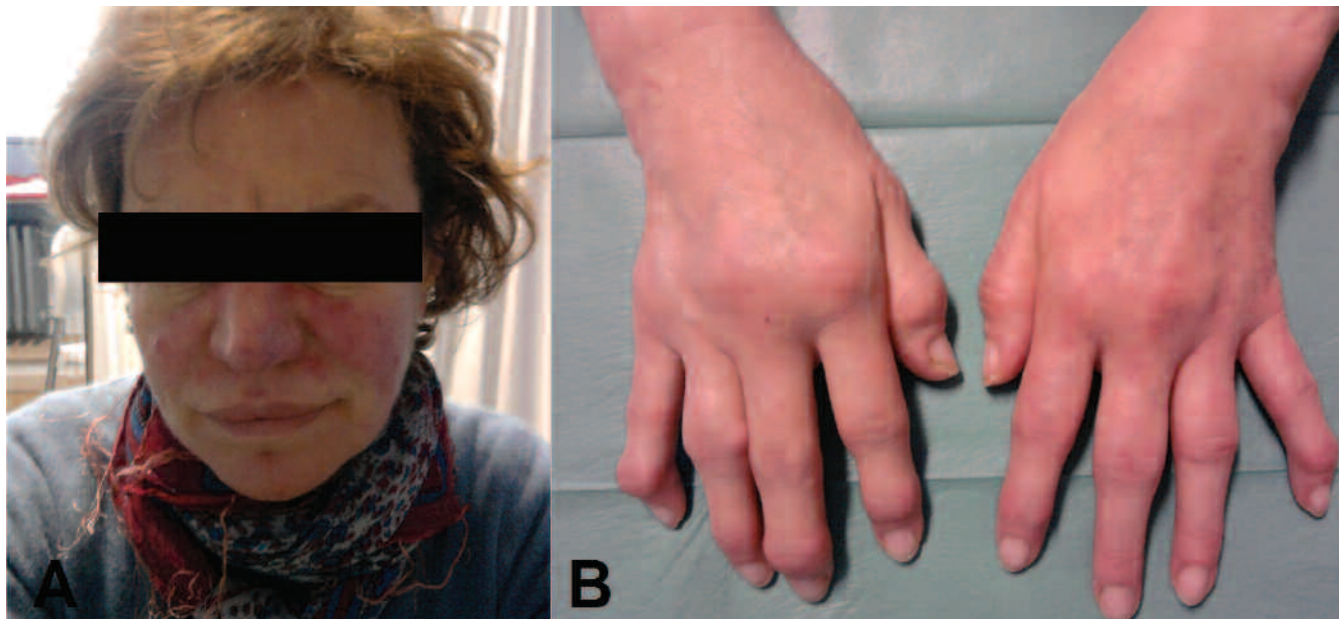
Clinical features of systemic lupus erythematosus (A, malar rash) and rheumatoid arthritis (B, radiograph-documented erosive polyarthrititis), consistent with diagnosis of rheupus syndrome.
